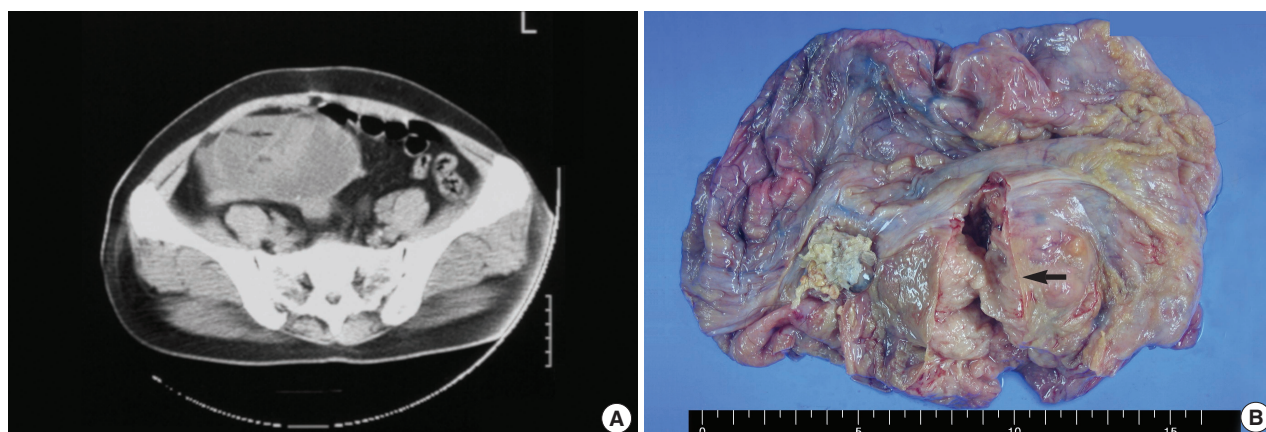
(A) Pelvic computed tomography demonstrates a cystic mass in the right ovary. (B) Cut section of the cyst reveals a solid polypoid area (arrow) on the inner surface. Yellowish creamy fluid and some hairs are also seen.
